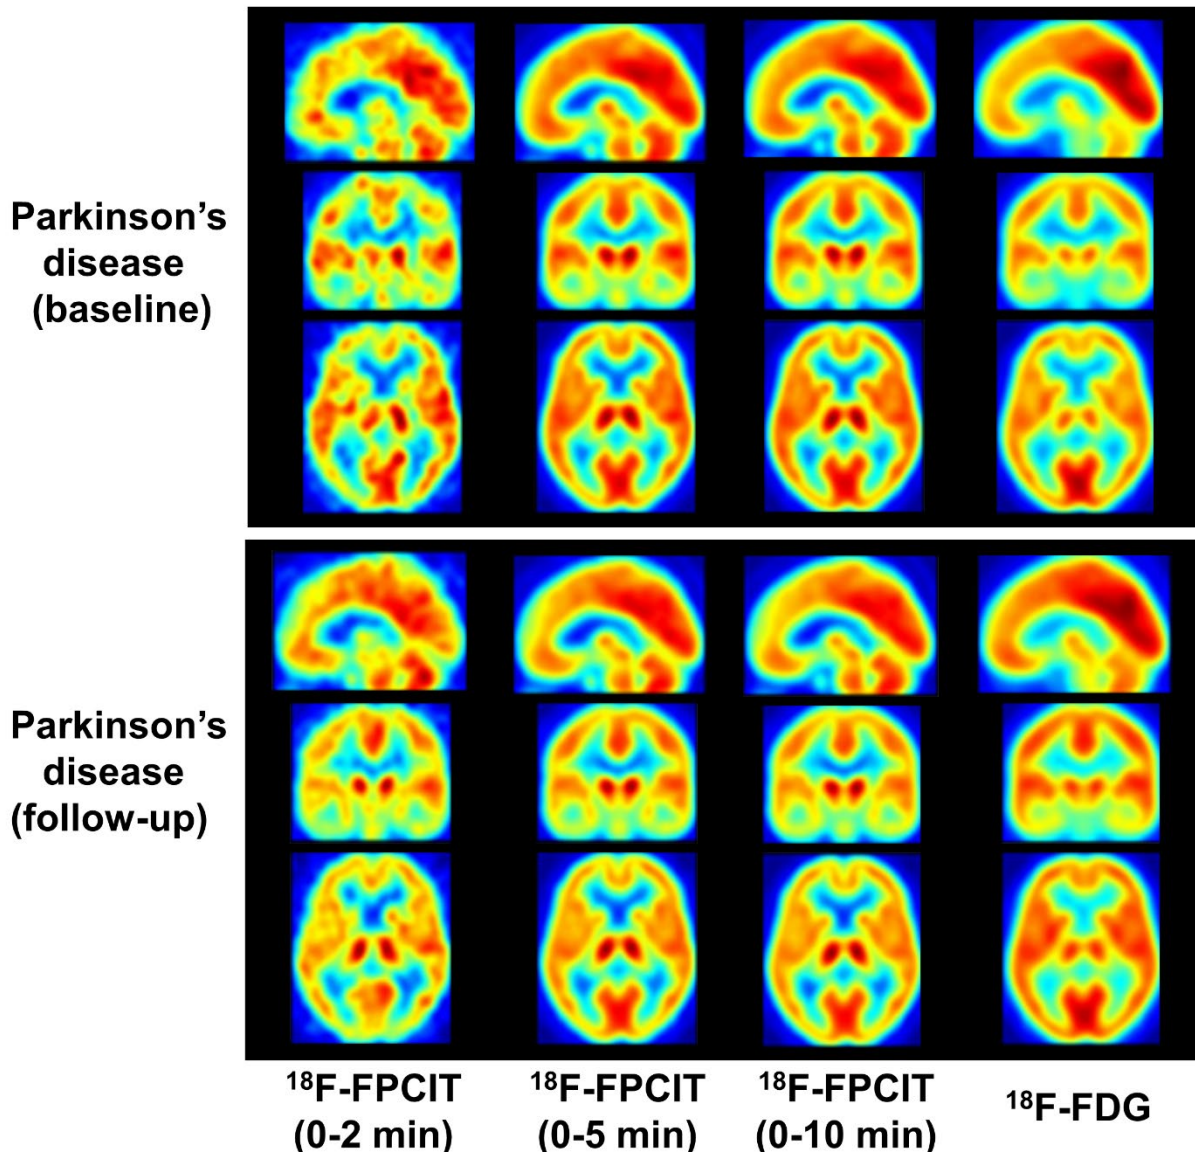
Mean images in PD patients at baseline and follow-up from early-phase ^{18}F -FPCIT and ^{18}F -FDG PET scans. There was high similarity between the mean images of ^{18}F -FPCIT over the first 2, 5 and 10 min post-injection and the corresponding ^{18}F -FDG images.
